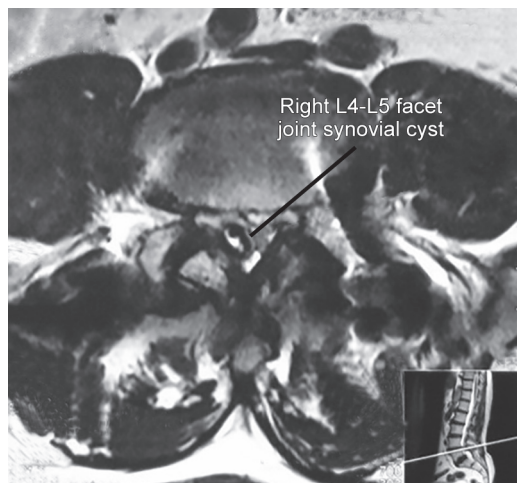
MRI transverse section at L3-L4 level depicting synovial cyst
